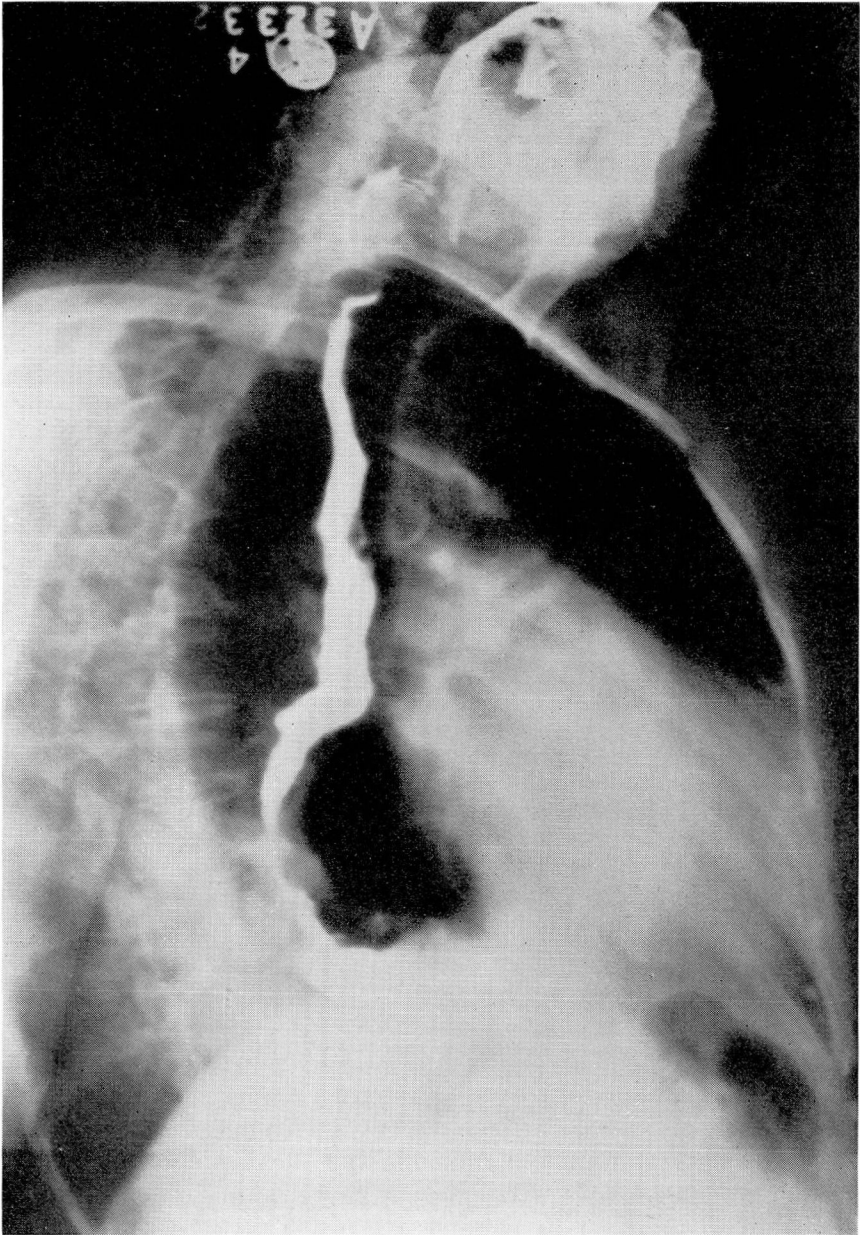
Roentgenogram showing esophagus of normal length.
